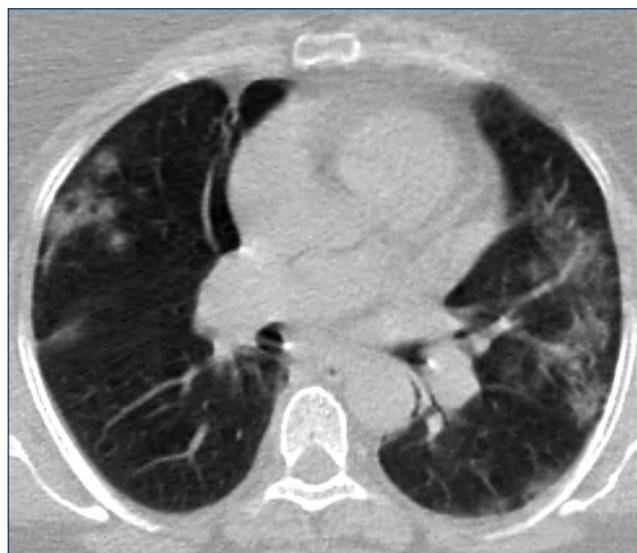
Thorax CT findings showing COVID-19 infiltration in the axial view.
